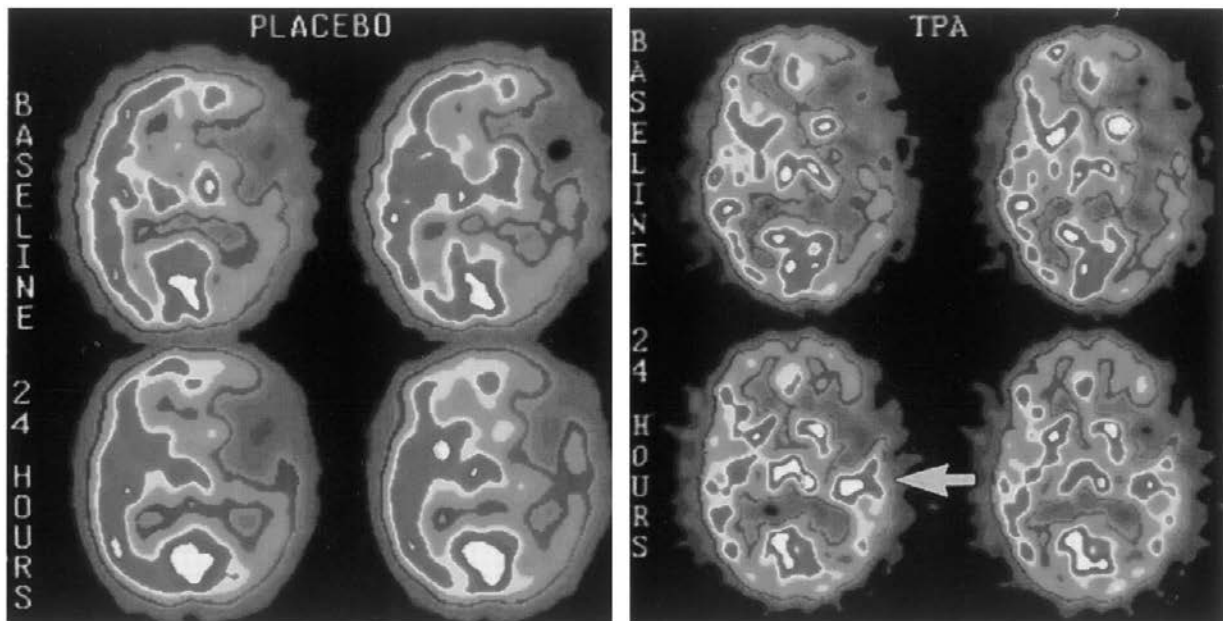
SPECT scan demonstrating restoration of flow following intravenous tissue plasminogen activator. The image on the left is a patient who received placebo. No significant improvement is noted. The image on the right demonstrates a significant flow improvement to the ischemic region (arrow). This patient dramatically improved within 24 hours after treatment. (From Grotta & Alexandrov, 1998, with permission.)
